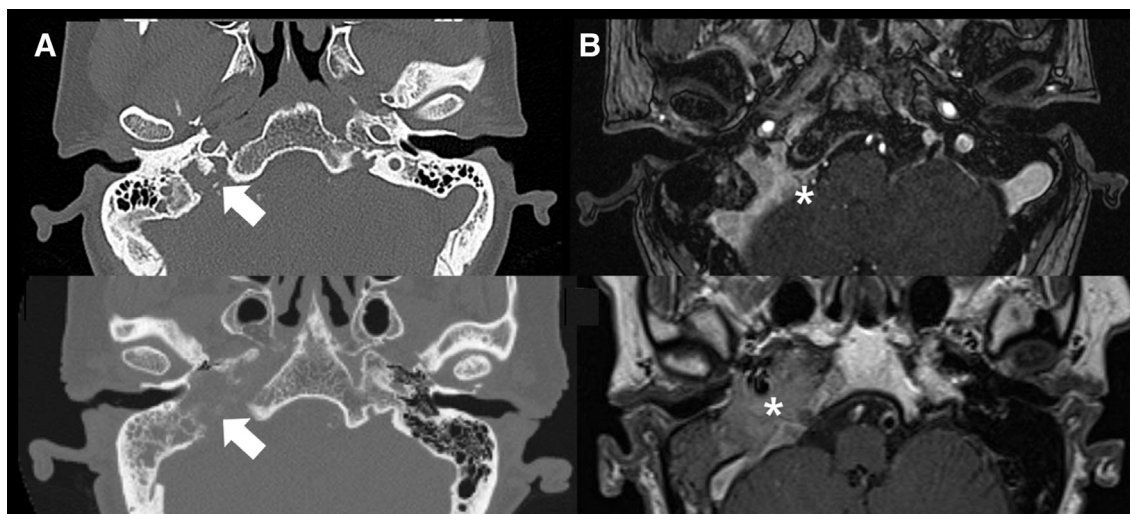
Features of computed tomography imaging in the jugular bulb area suggesting the presence of a temporal bone meningioma. (A) Widening and destruction of the jugular foramen are identified with temporal bone computed tomography images (white arrow). (B) Enhanced magnetic resonance imaging demonstrates the intracranial enhancing mass extending to jugular foramen and inducing the structural change of temporal bone in the jugular bulb area (white asterisk).
